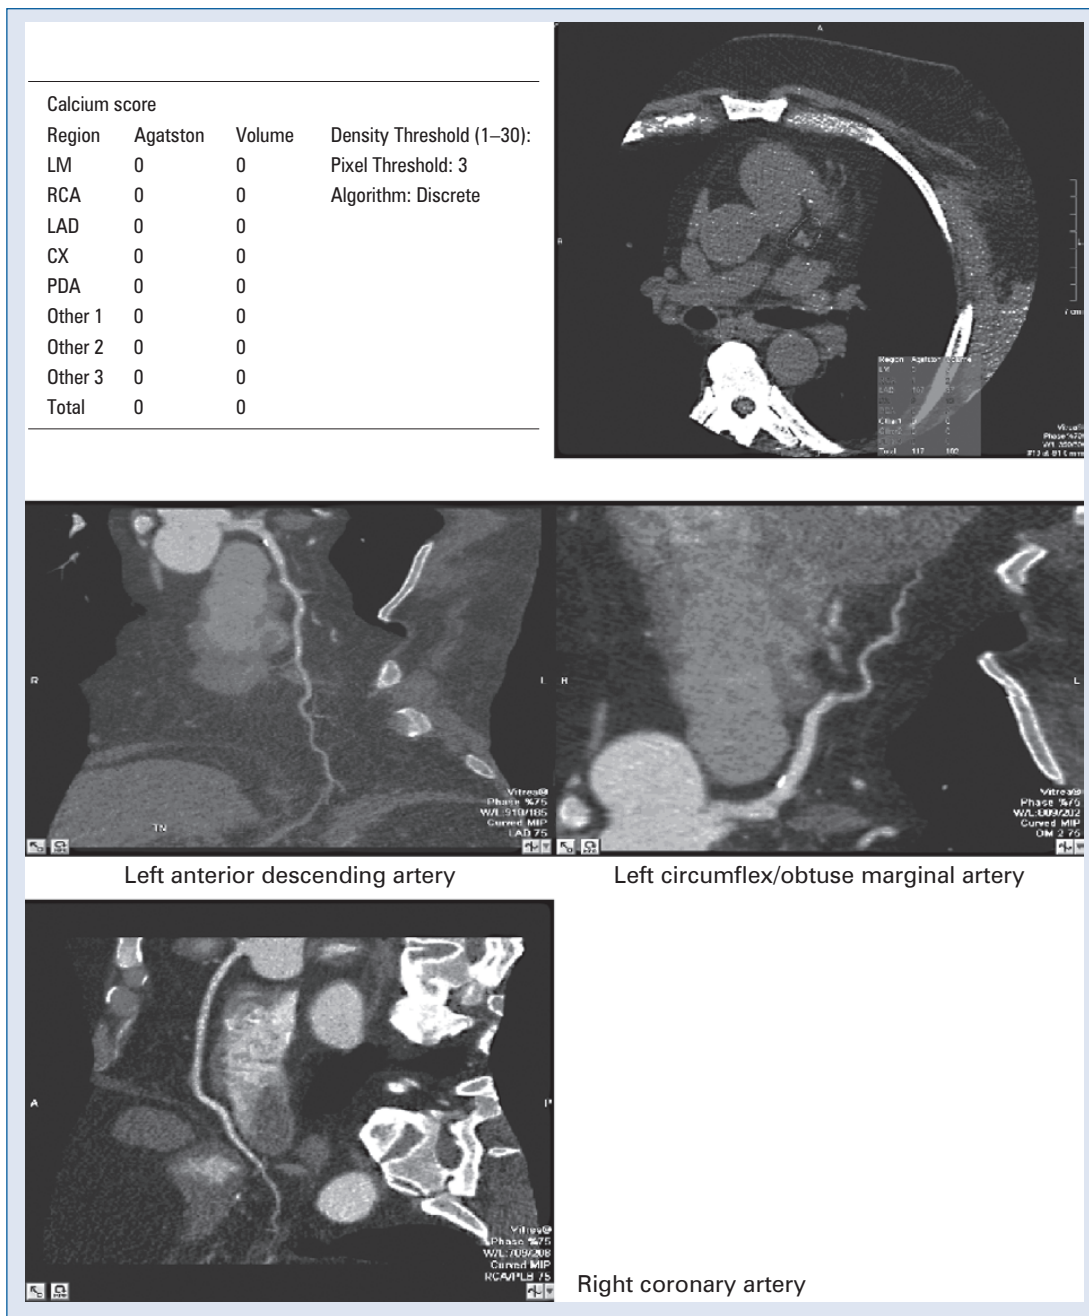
C. A 56 year-old female submaximal exercise echocardiography referred for additional stress myocardial perfusion imaging. Research CCTA shows no obstructive coronary disease.
